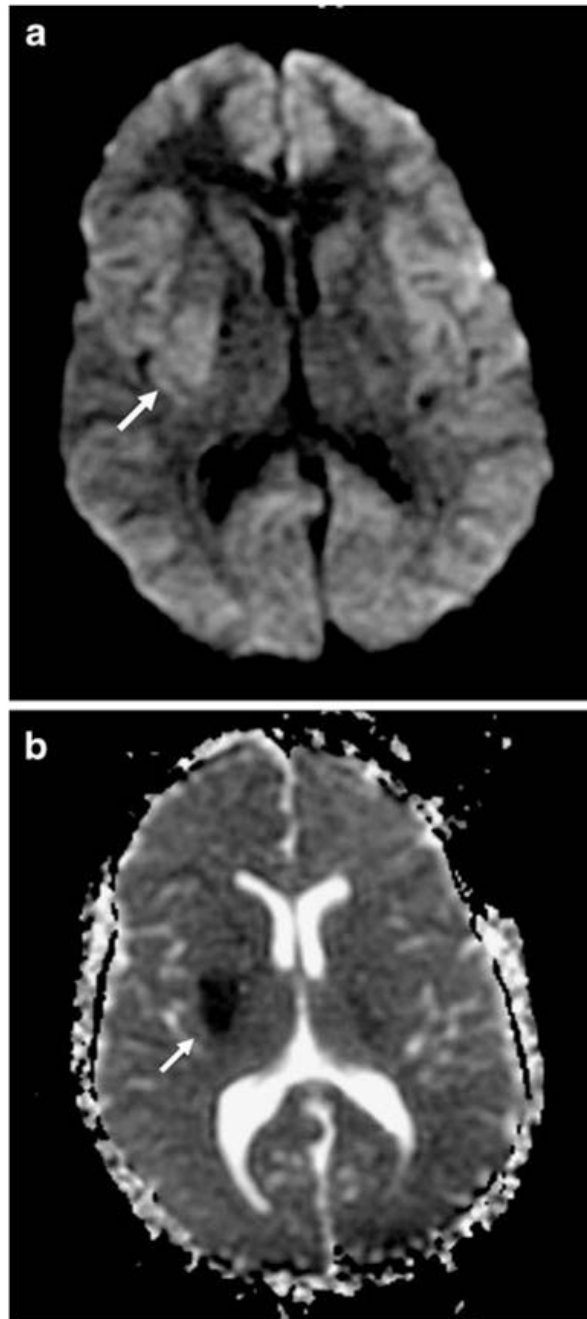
For case 1, diffusion-weighted MRI (a) shows faint bright signal, restricted diffusion, in the right basal ganglia. Apparent-diffusion coefficient image (b) is correspondingly *dark*, confirming acute ischemic infarction. *White arrows* indicate lesion site
